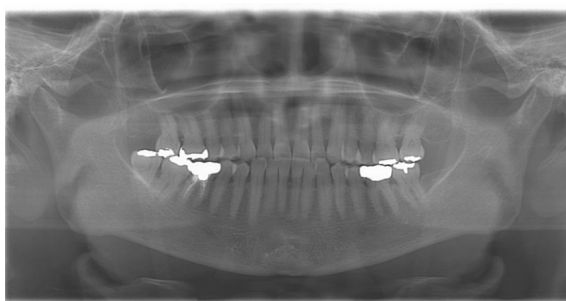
Panoramic radiograph showing no abnormalities in the temporomandibular joint or dentition.
